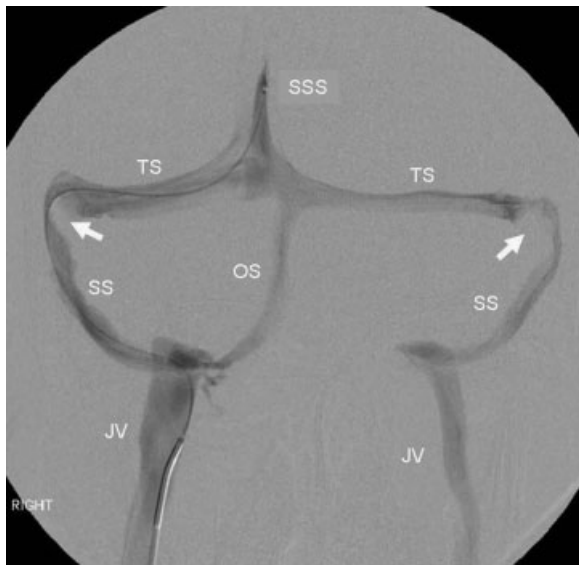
Catheter venogram, frontal view. Injection of radiographic contrast through a microcatheter into the superior sagittal sinus (SSS) outlines the transverse sinuses (TS), sigmoid sinuses (SS), and jugular veins (JV) on both sides and a right occipital sinus (OS). There are narrowings at the anterior ends of both transverse sinuses (arrows).
